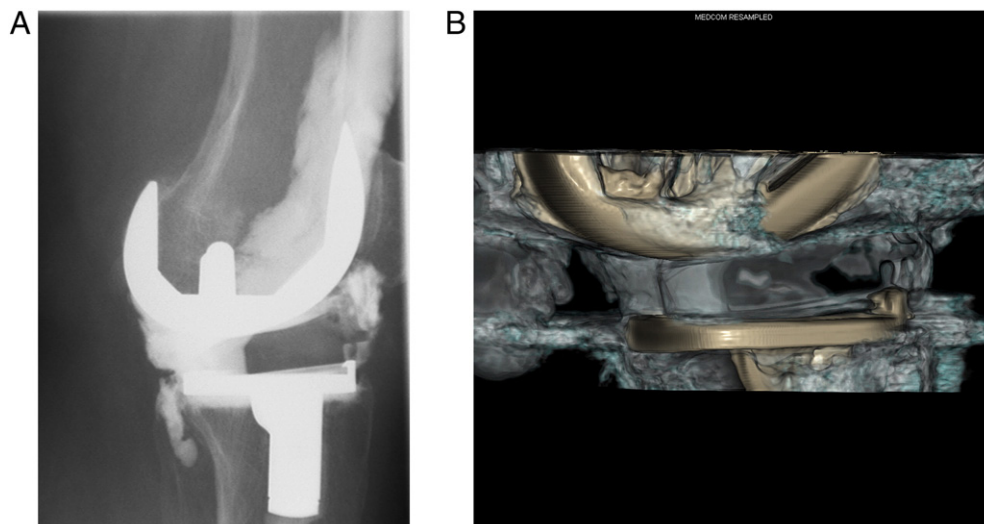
a) Arthrogram demonstrating detachment of the anterior polyethylene locking mechanism; b) confirmed by CT arthrogram three-dimensional reformation.
